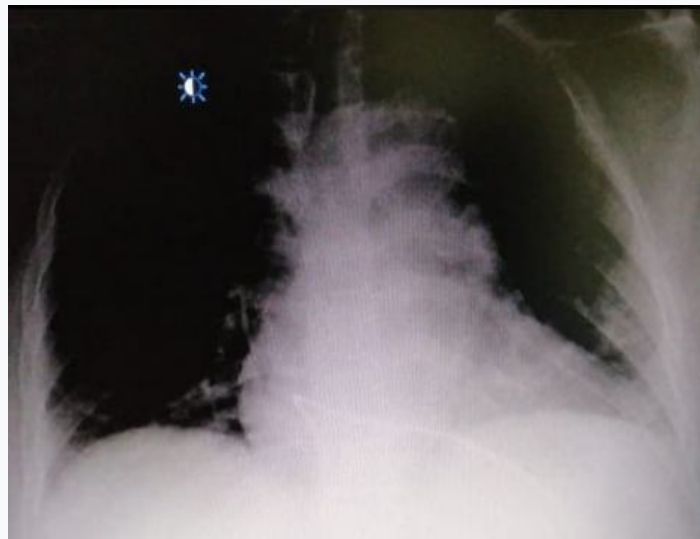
chest X-ray of the first patient showing the stimulation probe
